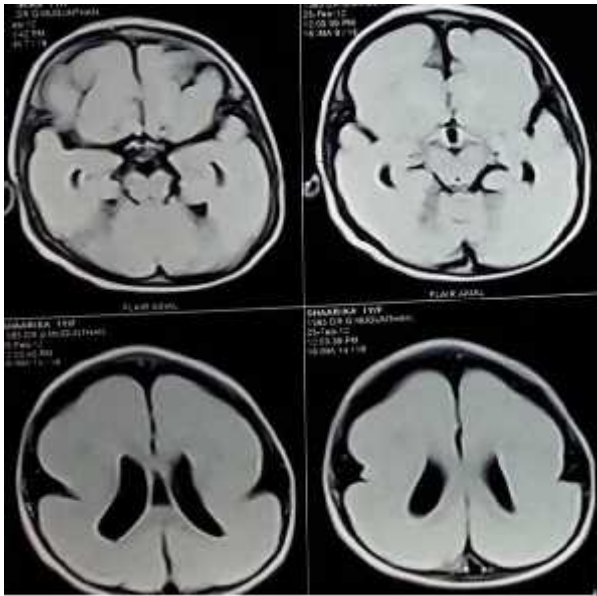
Malformation (Lissencephaly) – Axial FLAIR show smooth brain with absence of sulcogyral differentiation
